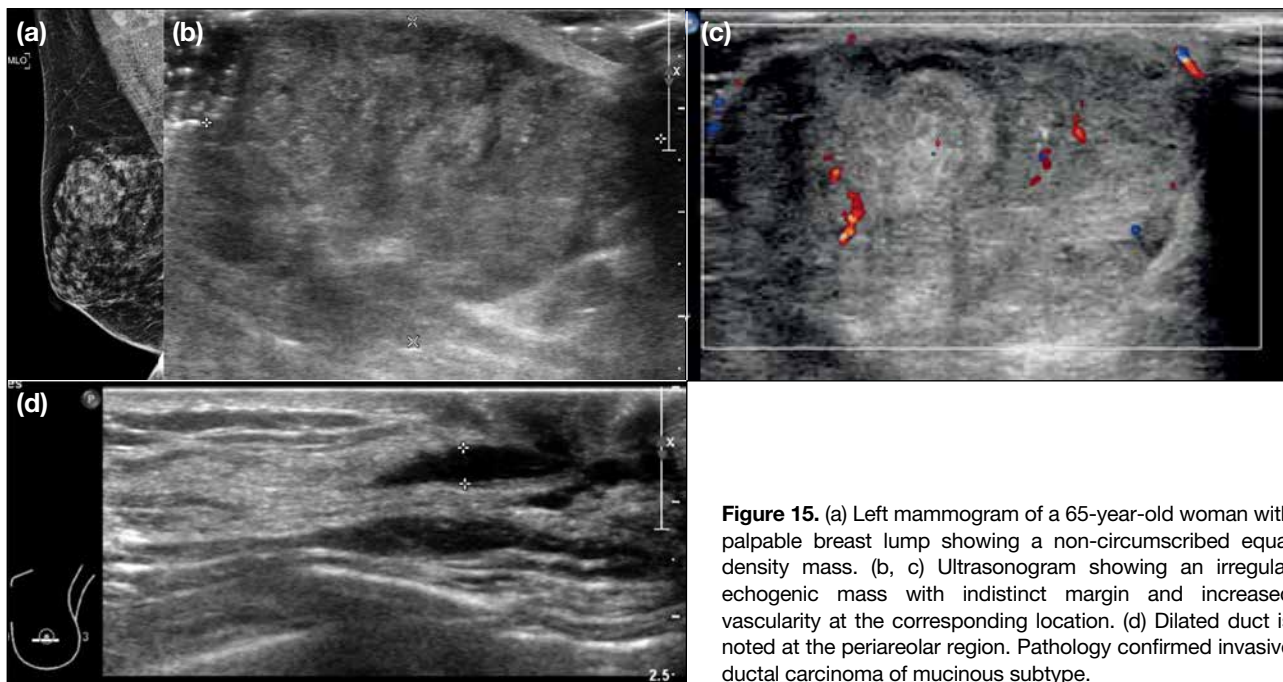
(a) Left mammogram of a 65-year-old woman with palpable breast lump showing a non-circumscribed equal density mass. (b, c) Ultrasonogram showing an irregular echogenic mass with indistinct margin and increased vascularity at the corresponding location. (d) Dilated duct is noted at the periareolar region. Pathology confirmed invasive ductal carcinoma of mucinous subtype.
